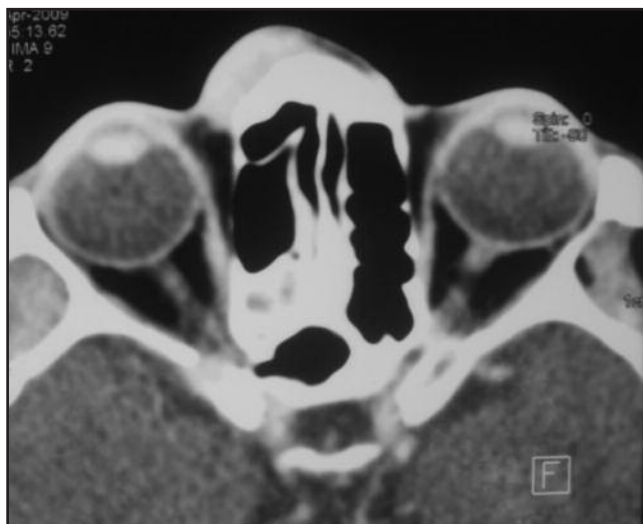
Computed tomography of paranasal sinuses showed a subcutaneous enhancing lesion over the right medial canthus without any bony erosion.
